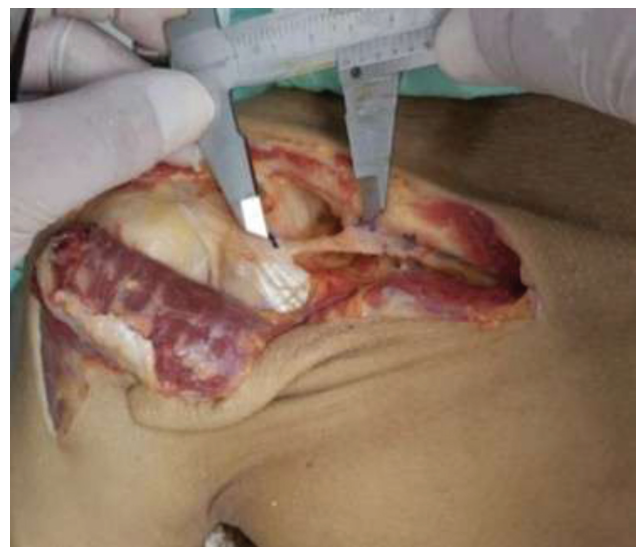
Dissection, structures identification and medial coracoclavicular ligament (LCCM) measurement; ACL, coracoacromial ligament; C, coracoid; CT, joint tendon; Pm, pectoralis minor; LCCL, lateral coracoclavicular ligaments; AS, anterosuperior band; PI, posteroinferior band.
